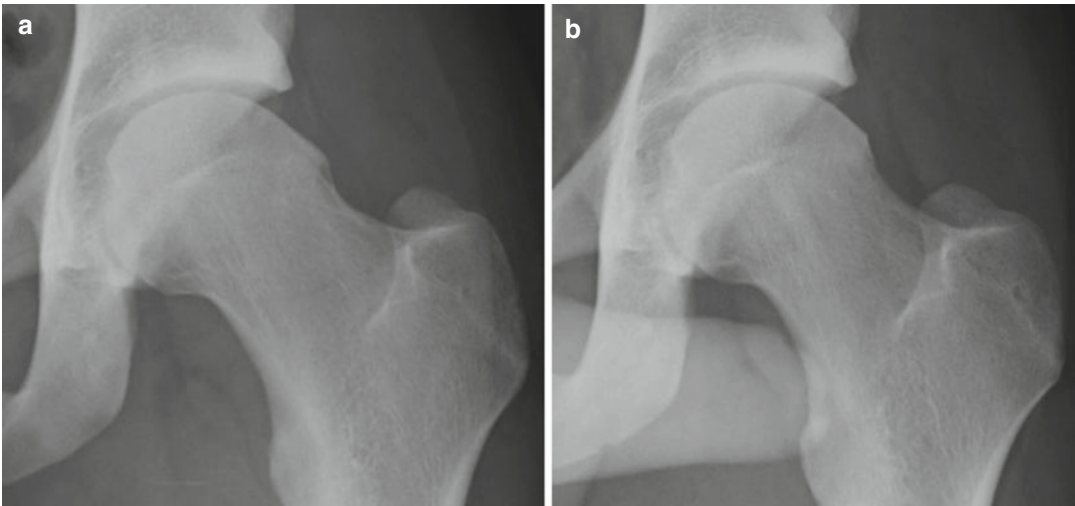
(a, b) Pre- and postoperative AP radiographs of right hip showing a successful arthroscopic resection of the posterolateral extension of cam lesion (Courtesy of Michael Dienst)
